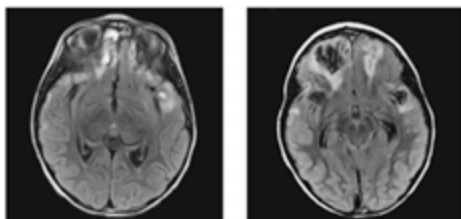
Clinical example Julia axial T2 FLAIR sequence taken 2 weeks post-injury. Figure 5-61 Clinical example Julia axial T2 FLAIR sequence taken 7 weeks post-injury.
